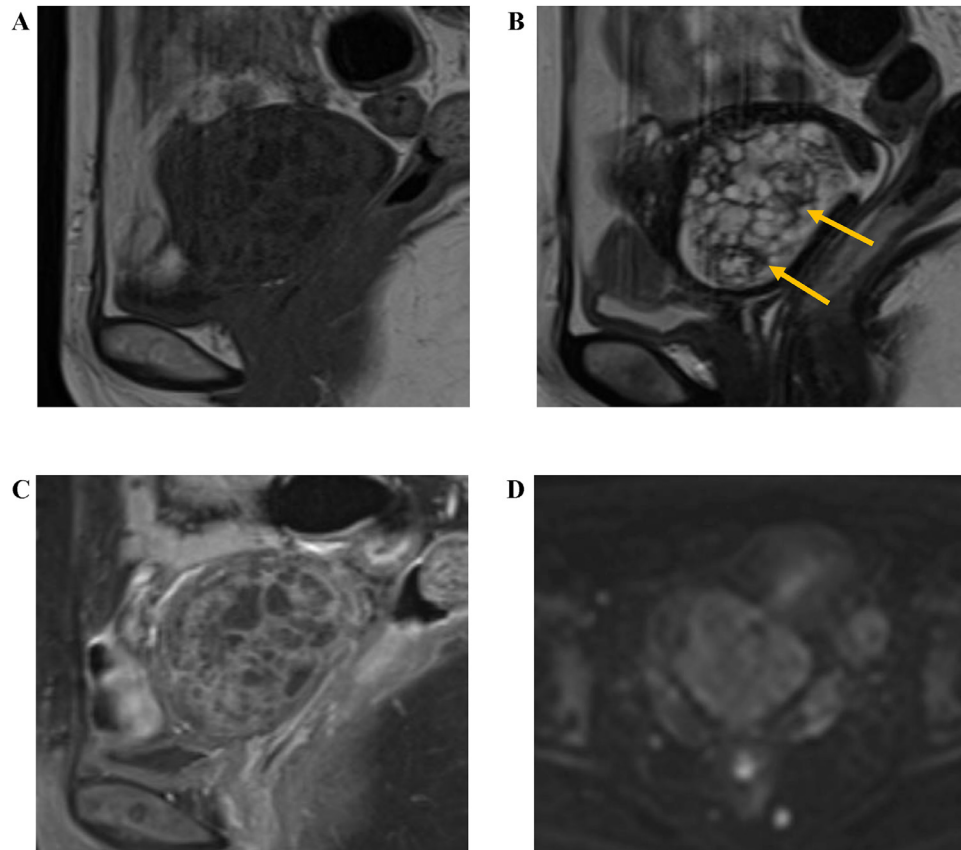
MRI of the uterine cervical tumor (A) sagittal T1WI, (B) sagittal T2WI, (C) sagittal contrast-enhanced image, (D) DWI. The tumor measures 5 x 4.5 cm in size and contains multiple cysts. The fluid content appears as a hypointense signal on T1WI and a hyperintense signal on T2WI. On T2WI, most of the septa within the tumor show a slightly hyperintense to slightly hypointense signal; however, some areas show a strong hypointense signal (arrow). The contrast effect on the septum is satisfactory. There is no hyperintense signal in the septum on DWI.
